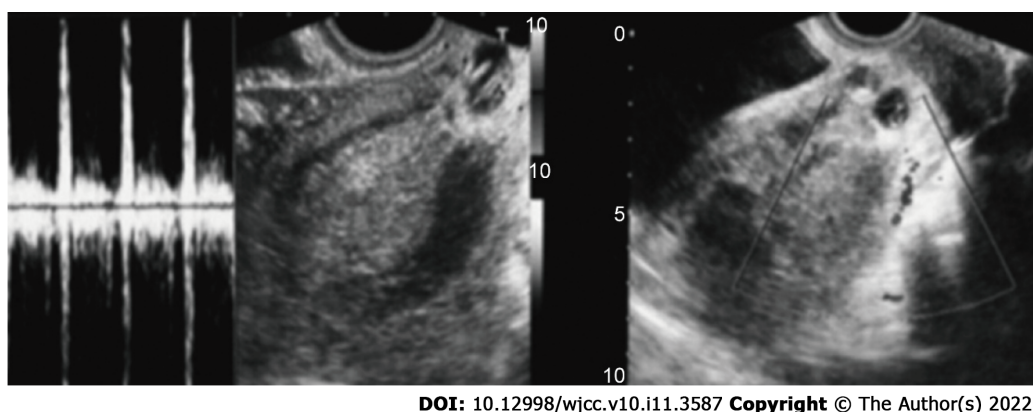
Transvaginal ultrasound findings in Case 2. A 30 mm gestational sac with fetal heartbeat was found in the cervix, and blood flow was noted around the sac by color Doppler imaging.
